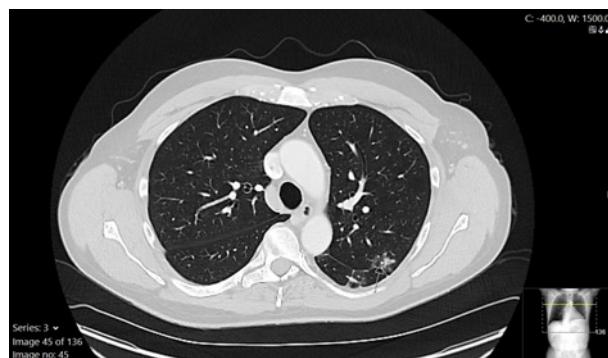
Routine follow-up CT imaging demonstrates a slight increase in size and density of the pre-existing LUL lesion (arrow), while all other lesions decreased in size.
